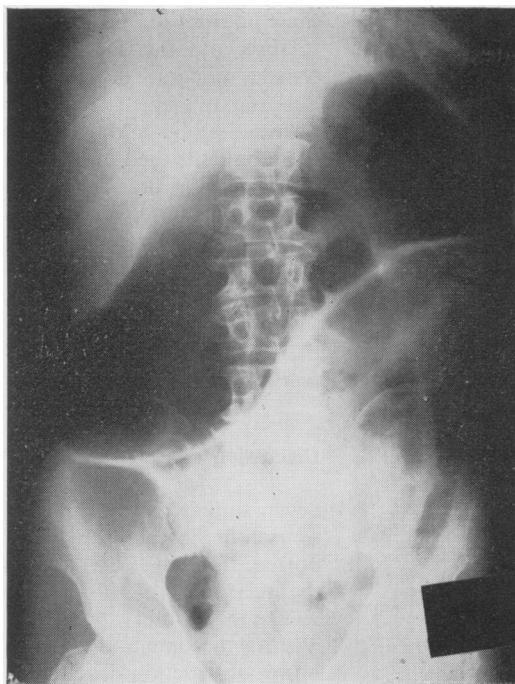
Plain radiograph of the abdomen shows gaseous distension of the colon as far as the splenic flexure, suggesting mechanical obstruction at this site.
